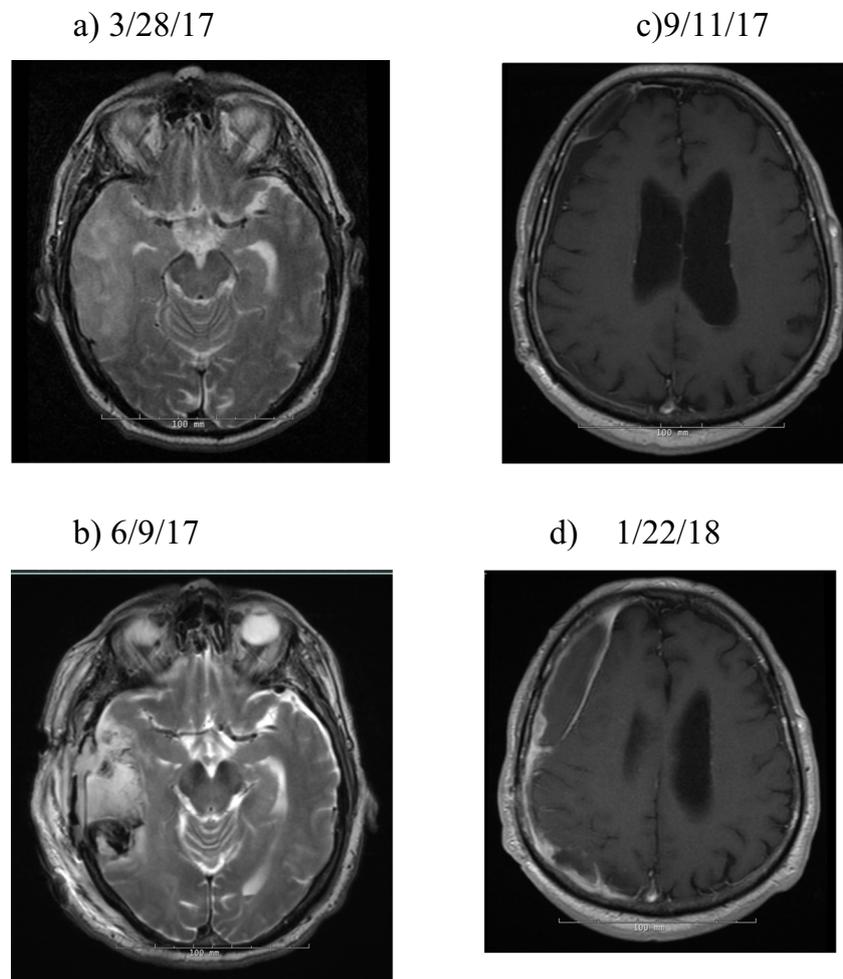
a: Preoperative axial T2 weighted MRI showing right temporal lesion
